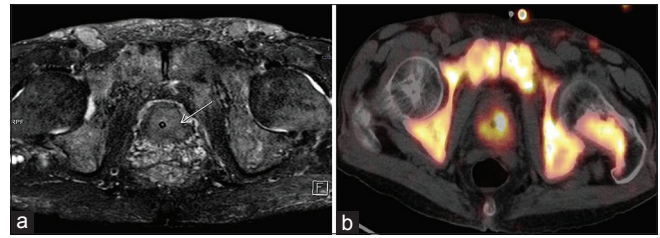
(a) Axial fat-saturated T2-weighted MR image shows hypointense nodular lesions (arrow) in the prostate base posteriorly on both sides of the midline. The pelvic bones and neck of left femur show heterogeneous signal consistent with metastasis. (b) Axial ⁶⁸Ga-PSMA PET/CT image at the same level as the MRI shows marked tracer accumulation in the corresponding areas of the prostate gland, pelvic bones, and left femur
